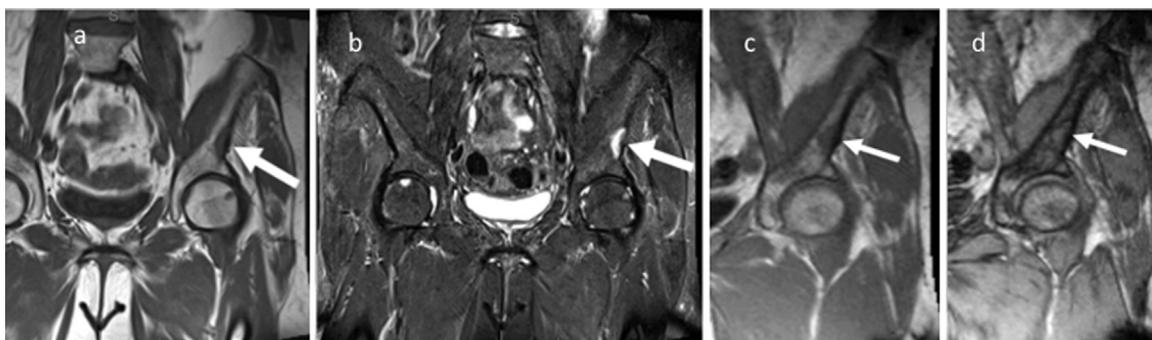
a–d: 2a – Coronal T1-weighted SE; TR: 547 ms, TE: 12 ms. 2b – Coronal short tau inversion recovery (STIR); TR: 3830 ms, TE: 50 ms, inversion time (TI): 150 ms. 2c – Coronal in-phase GRE; TR: 206 ms, TE: 4.6 ms, flip angle: 70°. 2d – Coronal opposed phase GRE; TR: 206 ms, TE: 2.3 ms, flip angle: 70°.
